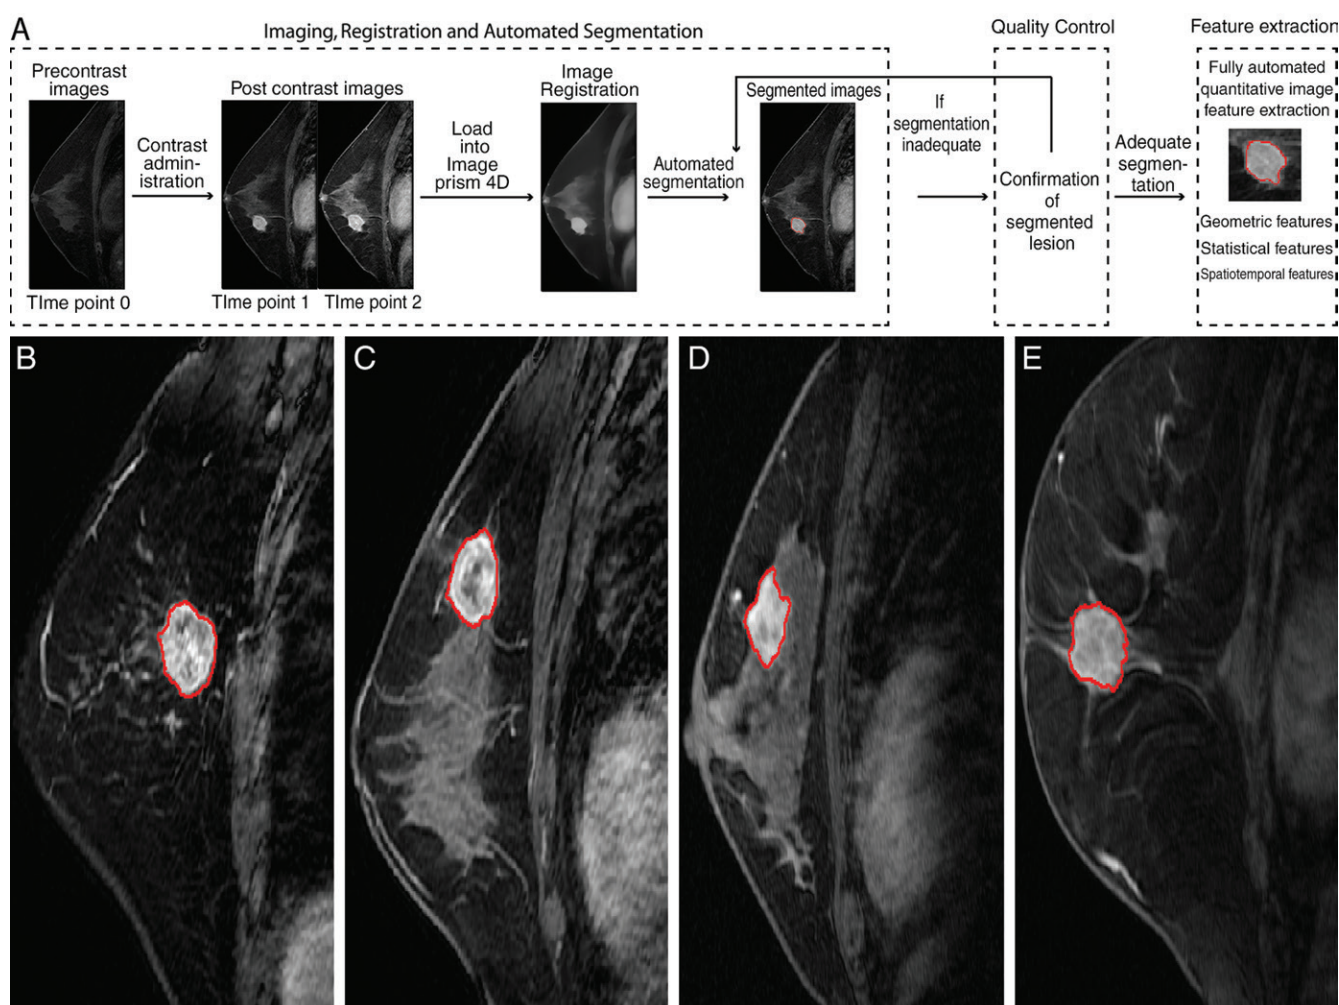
Sagittal images show, A, automated computer-vision DCE MR imaging analysis process. B, Image in a 67-year-old woman with estrogen and progesterone receptor–positive and human epithelial receptor type 2–negative invasive ductal carcinoma with ERF score of 0.72 (high ERF score). C, Image in a 56-year-old woman with estrogen and progesterone receptor–negative and human epithelial receptor type 2–negative invasive ductal carcinoma with ERF score of 0.83 (high ERF score). D, Image in a 64-year-old woman with estrogen and progesterone receptor–negative and human epithelial receptor type 2–positive invasive ductal carcinoma with ERF score of 0.0049 (low ERF score). E, Image in a 56-year-old woman with estrogen and progesterone receptor–positive and human epithelial receptor type 2 negative invasive ductal carcinoma with ERF score of 0.038 (low ERF score).
